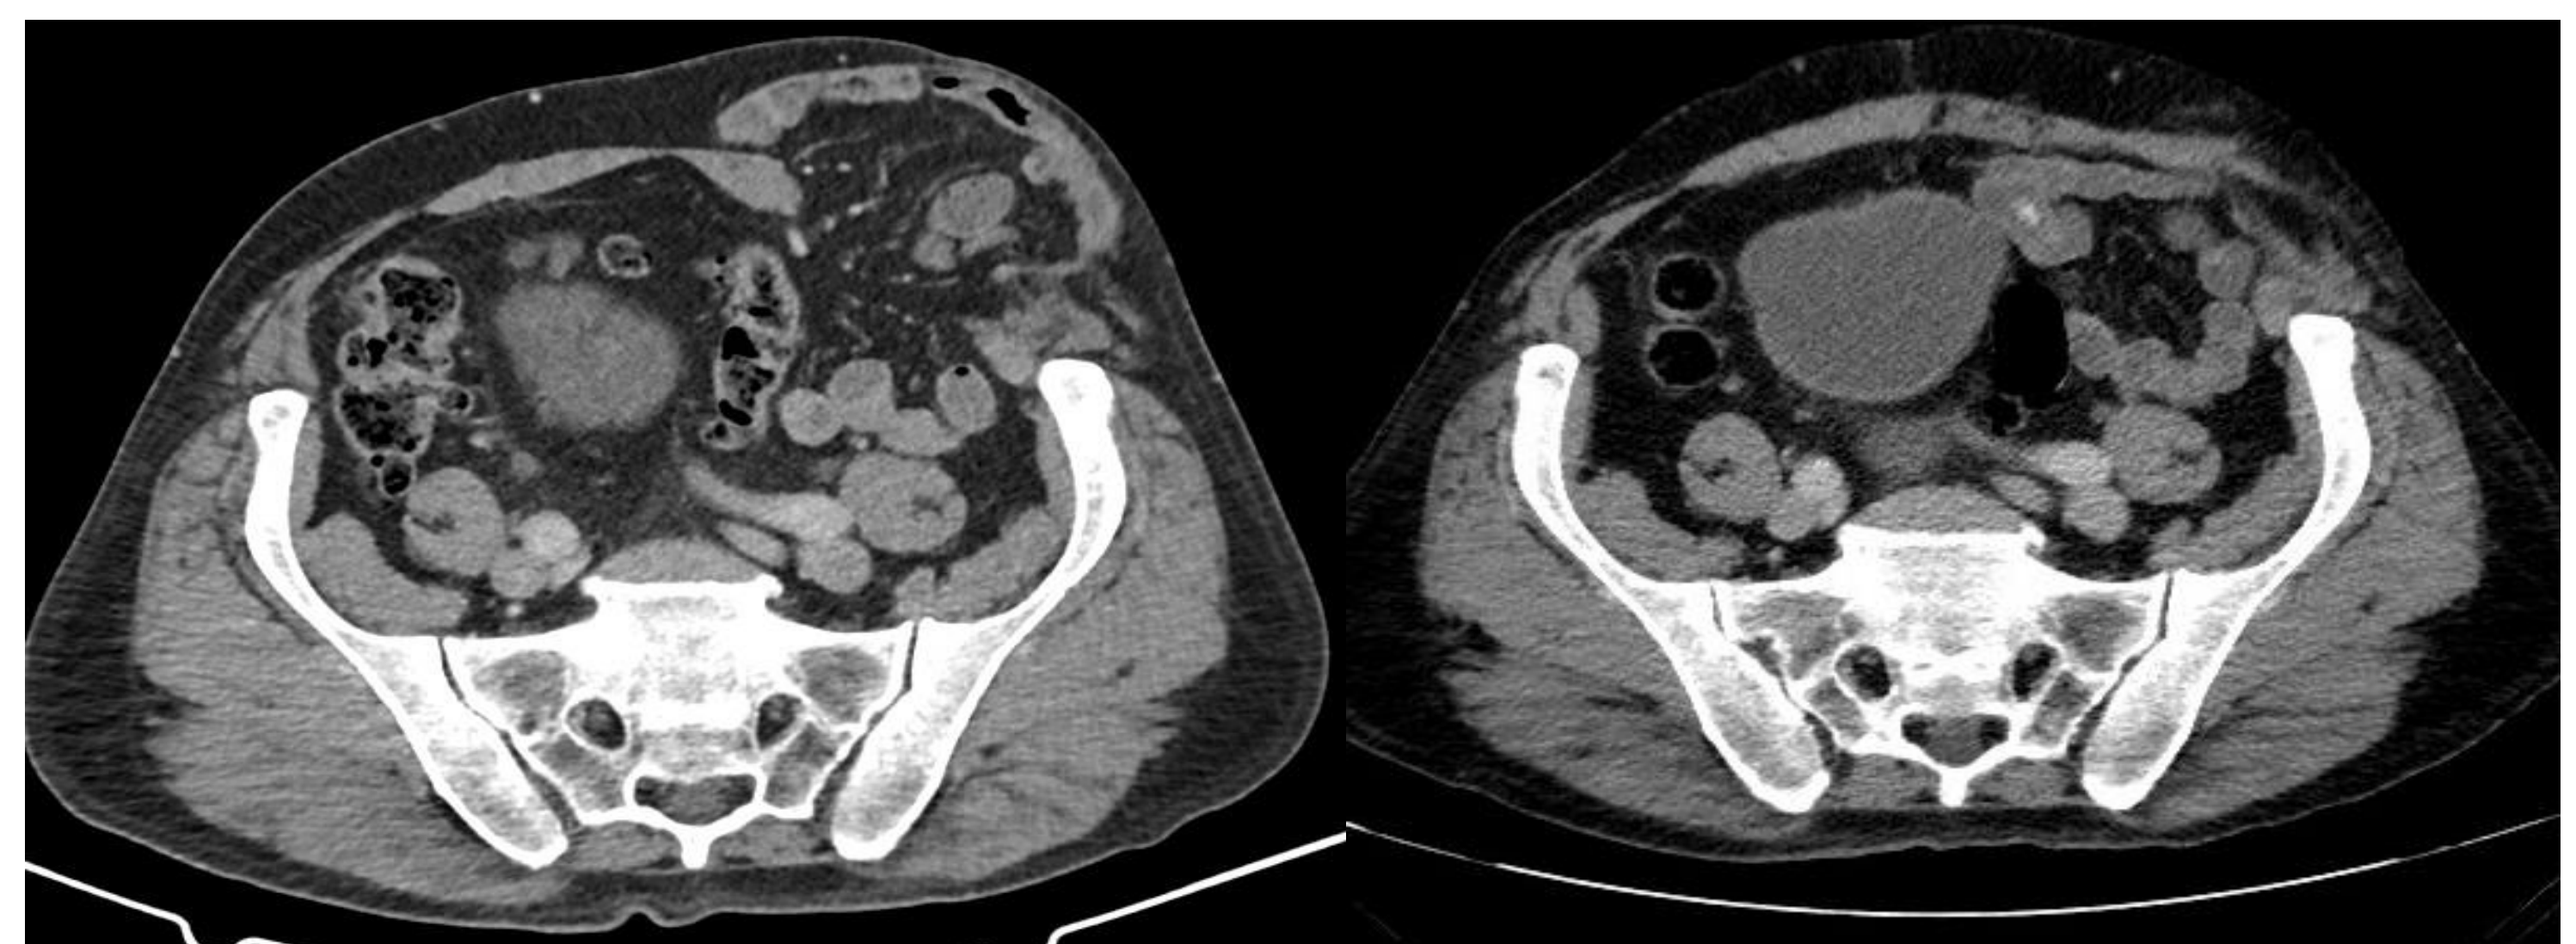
77 year old man with an incisional parastomal hernia following a laparoscopic high anterior resection. *Left:* CT axial slice of a large left-sided incisional hernia containing small bowel and its mesentery following ileostomy reversal. *Right:* Axial CT image 6 months post TAR repair showing anatomical reconstruction of the abdominal wall.
